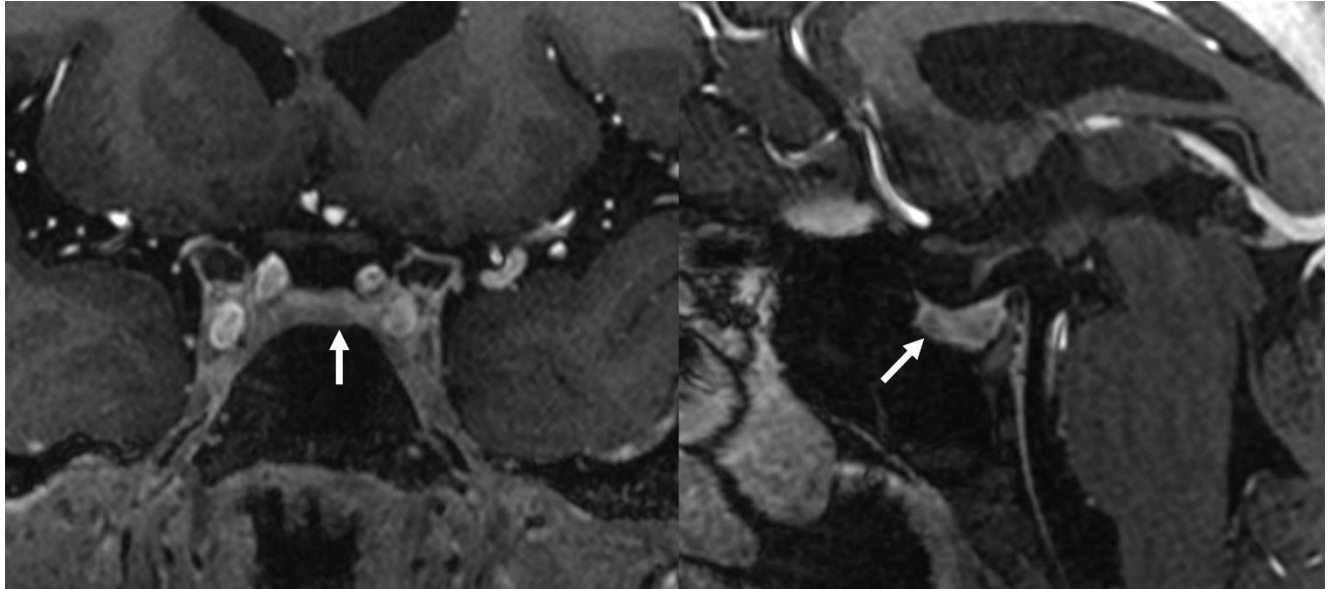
An example of 7T MRI showing a non-discrete lesion (arrows) in the left paramidline pituitary on postcontrast MPRAGE T1-weighted imaging at 0.33 mm that was a pathology proven Cushing adenoma.
